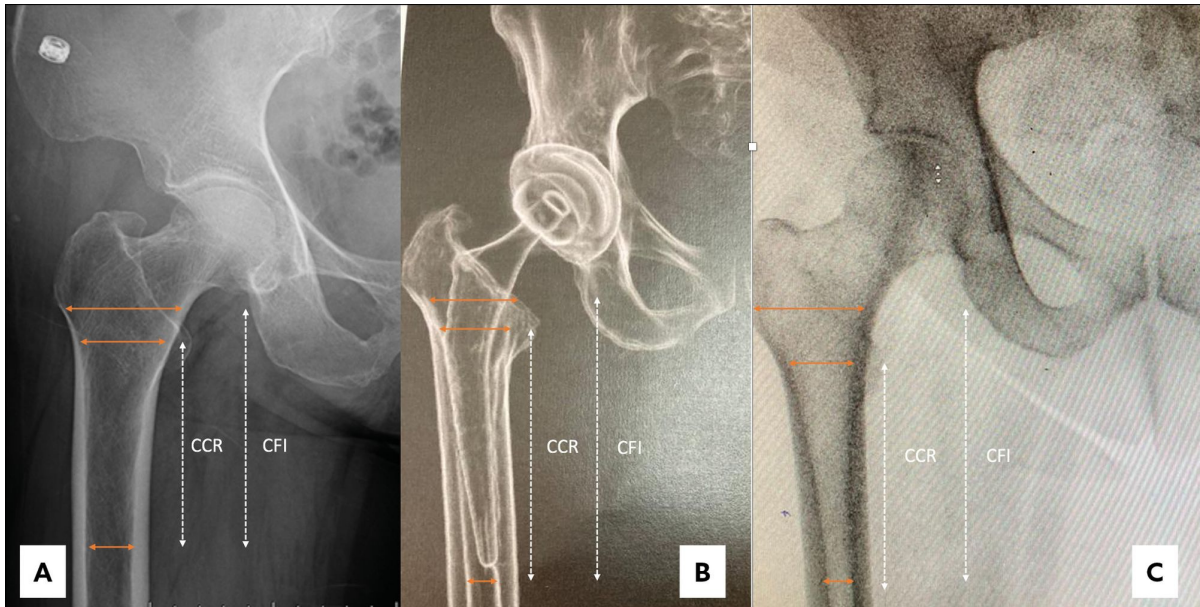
Radiographic measurements of CFI: (a) < 3.0 (stovepipe canal); (b) between 3.0 and 4.7 (normal canal); (c) > 4.7 (champagne-fluted canal).
